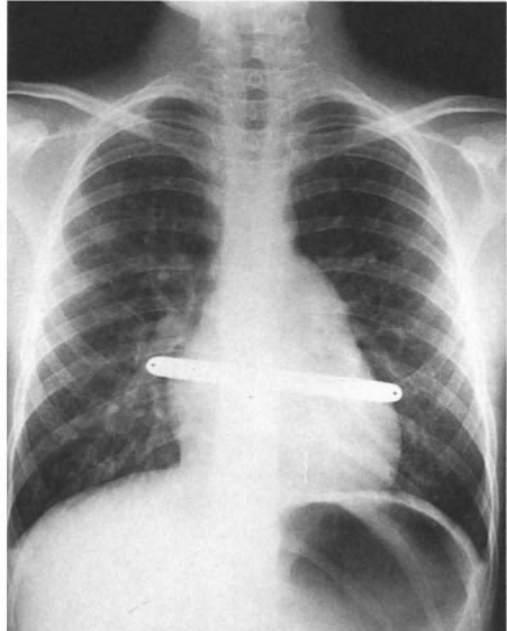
Postoperative X-ray shows retrosternal strut
